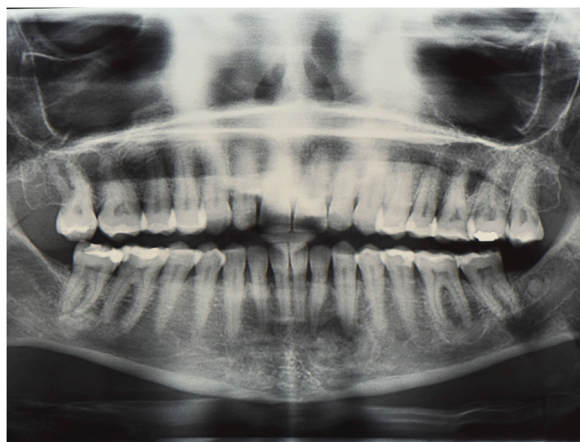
Orthopantomography (November 2021) showing no significant changes in radiological images.
